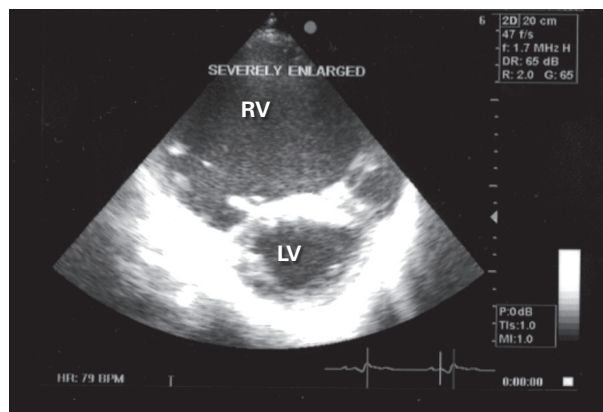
Transthoracic echocardiogram in short-axis view shows the left ventricle and the severely enlarged right ventricle.
